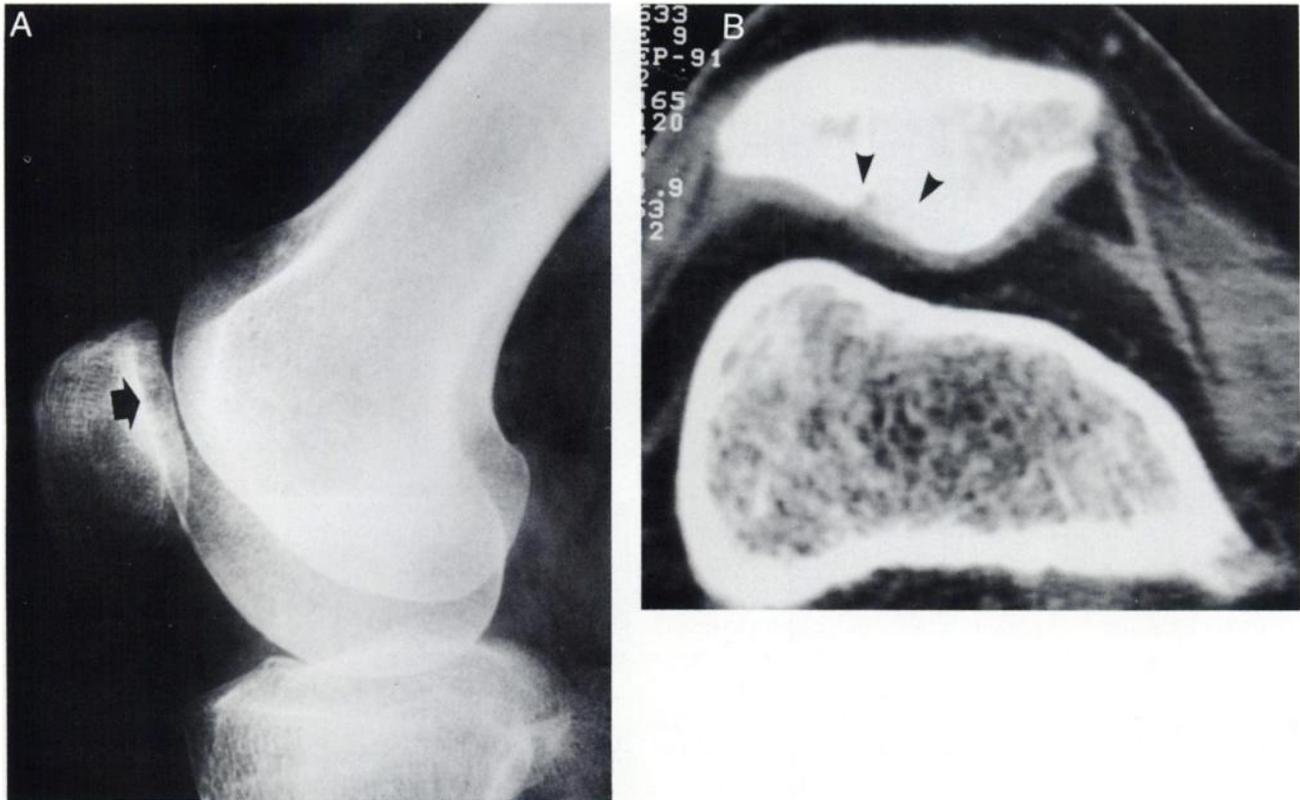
(A) Lateral x-ray of the right knee in Patient 4 with chondromalacia patellae shows a small, spotty lysis in the central retropatellar facet (arrow) and bone sclerosis with "excavation" (vertical, opaque meniscus-like shadow about arrow). Neither osteophyte nor other articular alterations are present. (B) A low-window-set axial CT scan through the patella reveals both roughened and thinned facet cartilage and subchondral cystic change (arrowheads).
